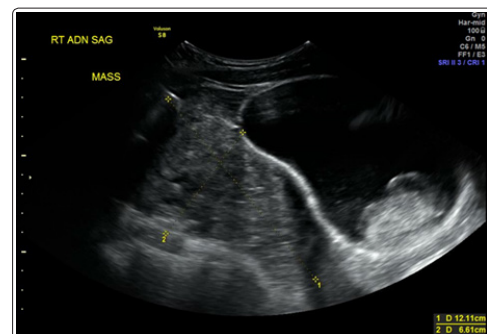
Pelvic ultrasound showing a 12cm right ovary and a distended bladder despite urinary catheter with an intravesicular blood clot (astrix)
